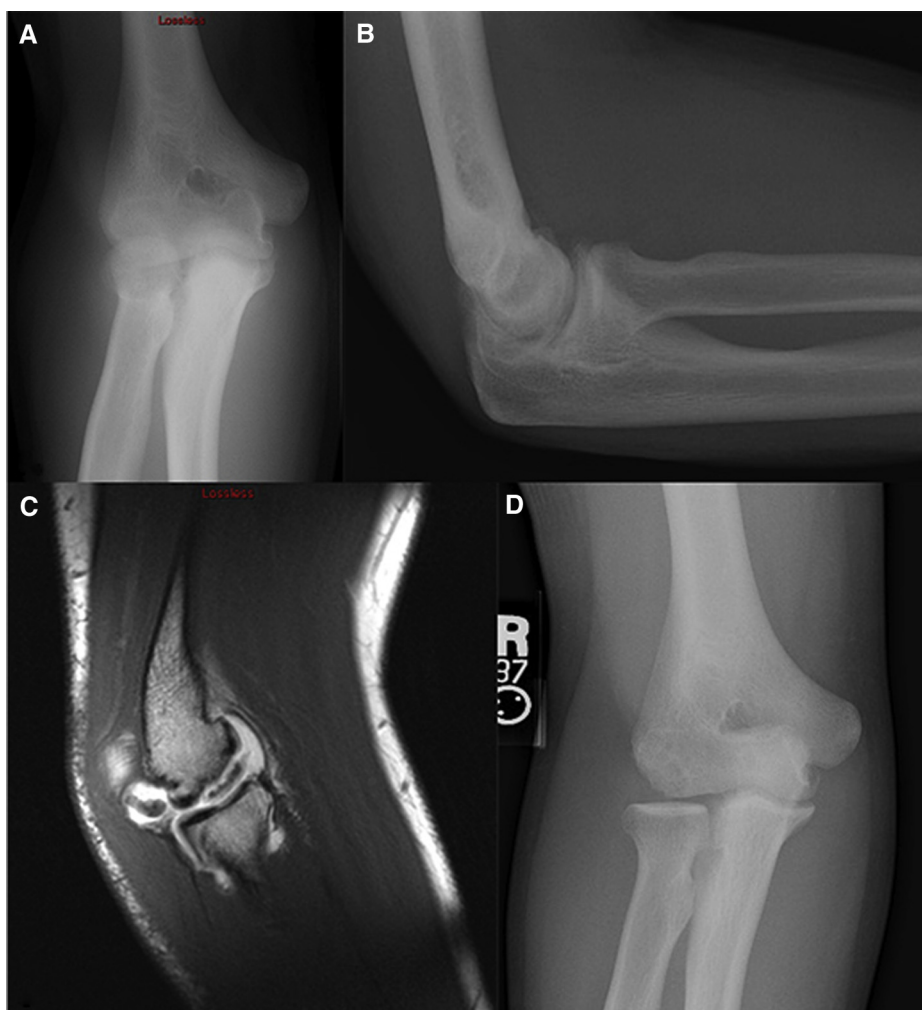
Preoperative (A) anteroposterior and (B) lateral X-ray images and (C) a sagittal T2-weighted magnetic resonance image of a 16-year-old pitcher with right elbow pain and loss of full elbow extension demonstrated a 20×15 mm osteochondritis dissecans with large loose bodies. The patient underwent right elbow arthroscopy with débridement and removal of loose bodies, followed by an open osteochondral autograft transfer procedure with two 4-mm plugs and two 6-mm plugs harvested from the ipsilateral knee. (D) Radiographs obtained at 3 months postoperatively demonstrated excellent incorporation of the graft.
